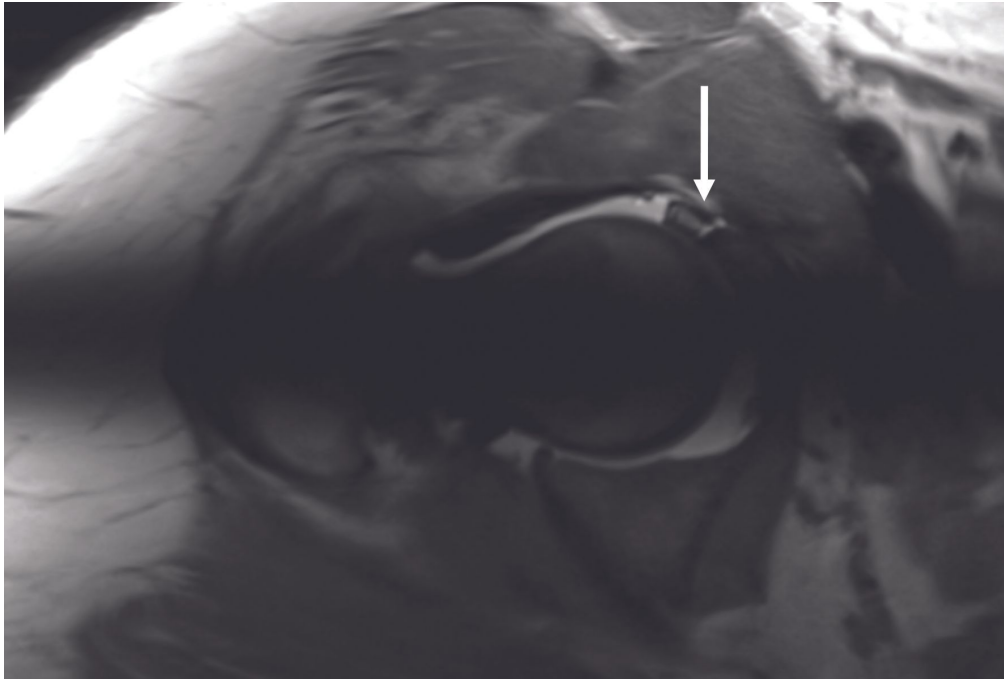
Lesions of the labrum. Arthro-MRI is the examination of choice for visualising labrum lesions, which are most often located anterosuperiorly in the joint (white arrow).
